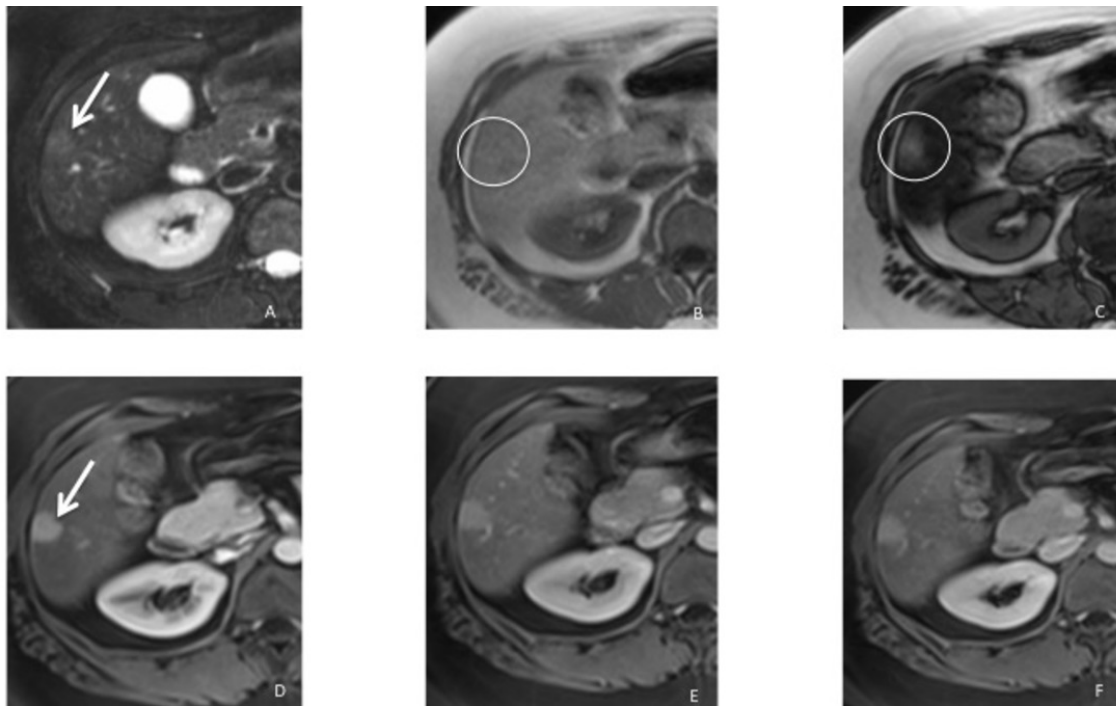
Inflammatory hepatocellular adenoma. Axial T2-weighted fat-saturated imaging (A) and T1-weighted (B) MR images show a focal hepatic lesion that are slightly hyperintense on the T2-weighted image (arrows in A) and isointense to slightly hyperintense on the T1-weighted image (B). Axial T1-weighted in-phase (B) and out-of-phase images (C) show an important signal drop of the liver on the opposed-phase image -> Diffuse fat deposition. Contrast-enhanced T1-weighted MR images show the lesion with intense arterial phase enhancement (arrows in D), which persists into the portal venous phase and in the delayed phase (E and F).
